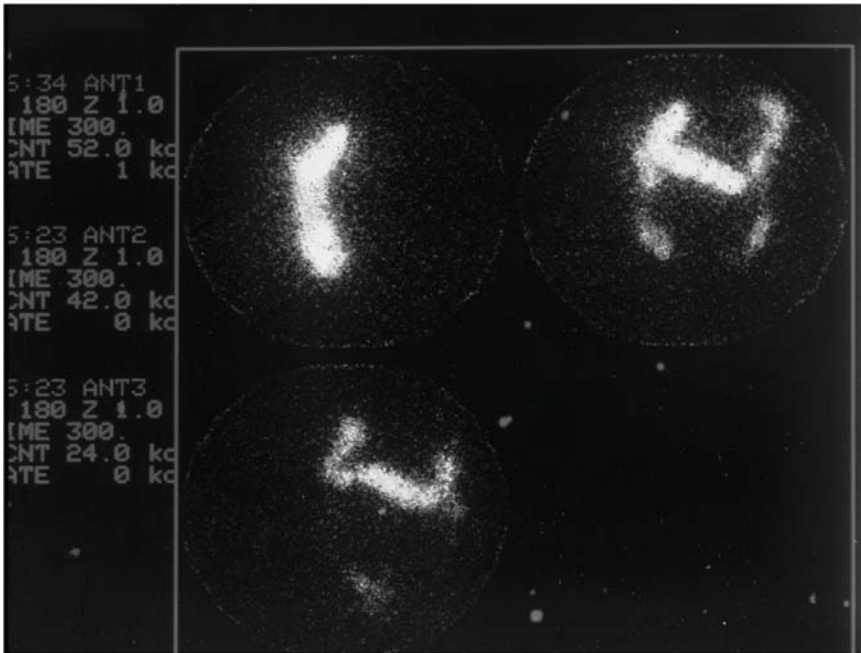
Oral scintigraphic segmental transit study.
